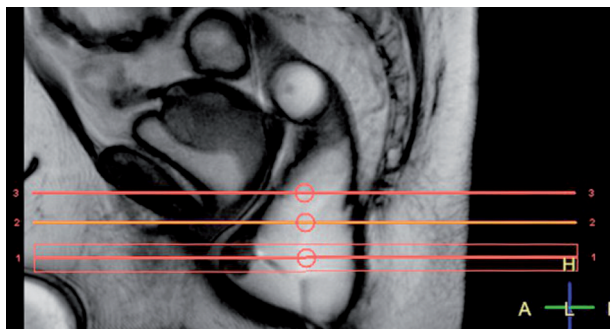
(A) Positioning of three contiguous, horizontal 10-mm-thick-sections relative to the symphysis pubis and to the deepest position of pelvic organs for standard MR image acquisition in the axial plane of the levator hiatus on straining: section n° 3 = level of midsymphysis; section n° 2 = level of arcuate ligament; section n° 1 = level of the most prominent bulging of anterior rectal wall. (B) Levator hiatus enlargement under the effect of straining in a steady state. A = area; numbers are square mm.
